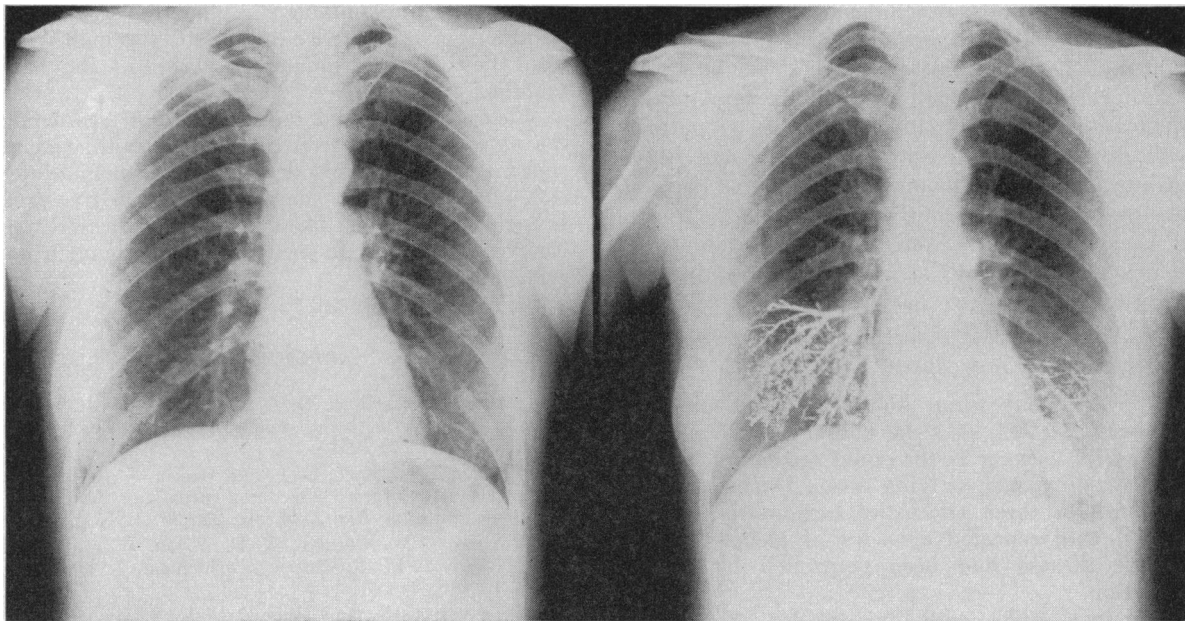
Roentgenograms with contrast medium, showing extensive bronchiectasis in left lower lobe.
